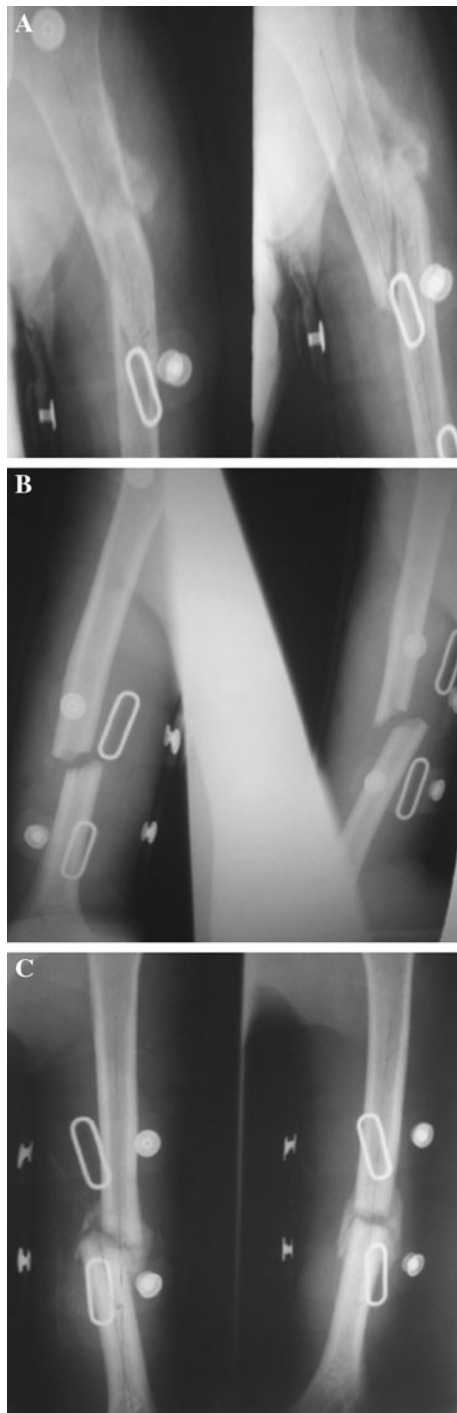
a AP and lateral radiograph 14 weeks after application of brace. b Anteroposterior and lateral radiograph of another patient with application of functional brace. c AP and lateral radiograph of same patient 10 weeks after application of brace
